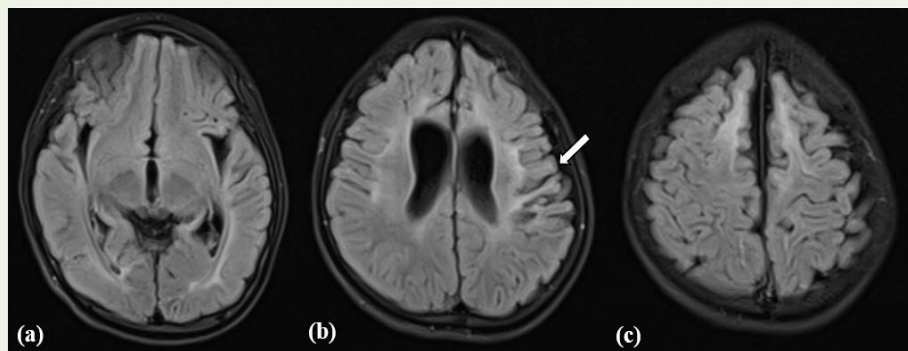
Fluid-attenuated inversion recovery (FLAIR) images showing subcortical and periventricular white-matter hyperintensity at the level of the (a) temporo-occipital lobes, (b) parietal lobes with small, atrophic, mushroom-shaped gyri with sparing of the gyral crests (ulegyria) are seen in the (white arrow), with and ex vacuo dilatation of the lateral ventricles and (c) frontal lobe.
